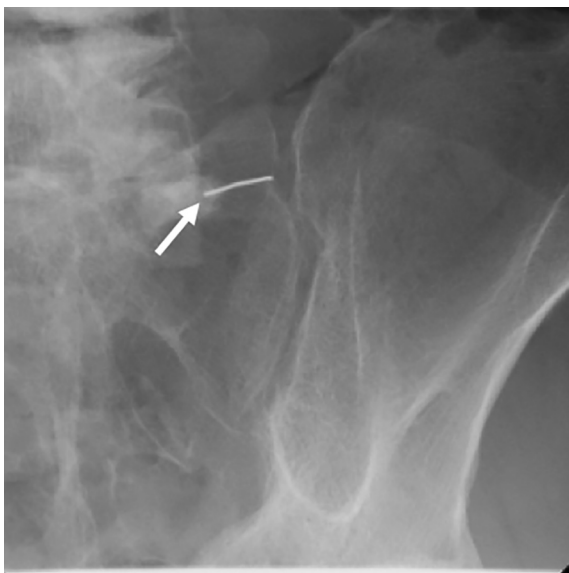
Radiograph at the time of the puncture. Needle for nerve block (white arrow).
